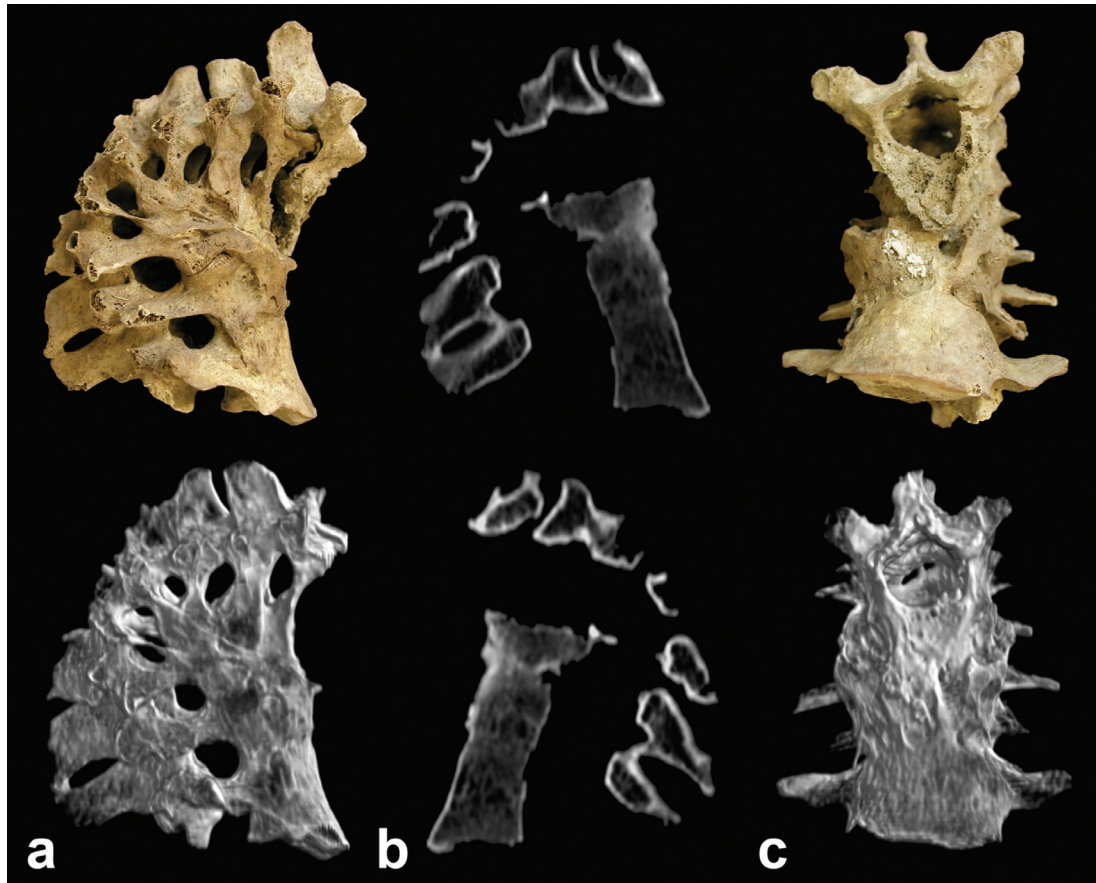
Advanced stage Pott's disease. Morphological pictures, CT images and 3D reconstructions of the thoracolumbar spine remains from the Nyárlőrinc medieval cemetery (Grave 82).
